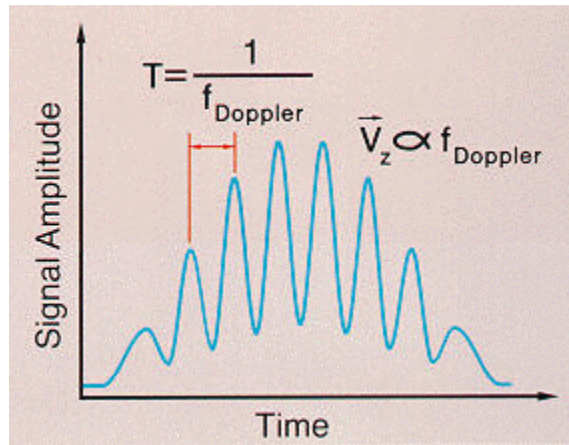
Doppler Burst pattern resulting from a particle crossing the LDV probe volume fringes. Adapted from <http://clients.dedicatedconsulting.com/aerometrics/ldv.html>.
